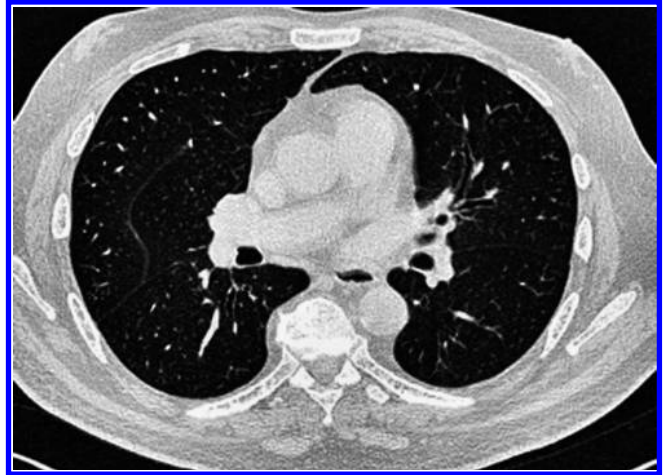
CT scan after 3 months showing resolution of the lesions.
